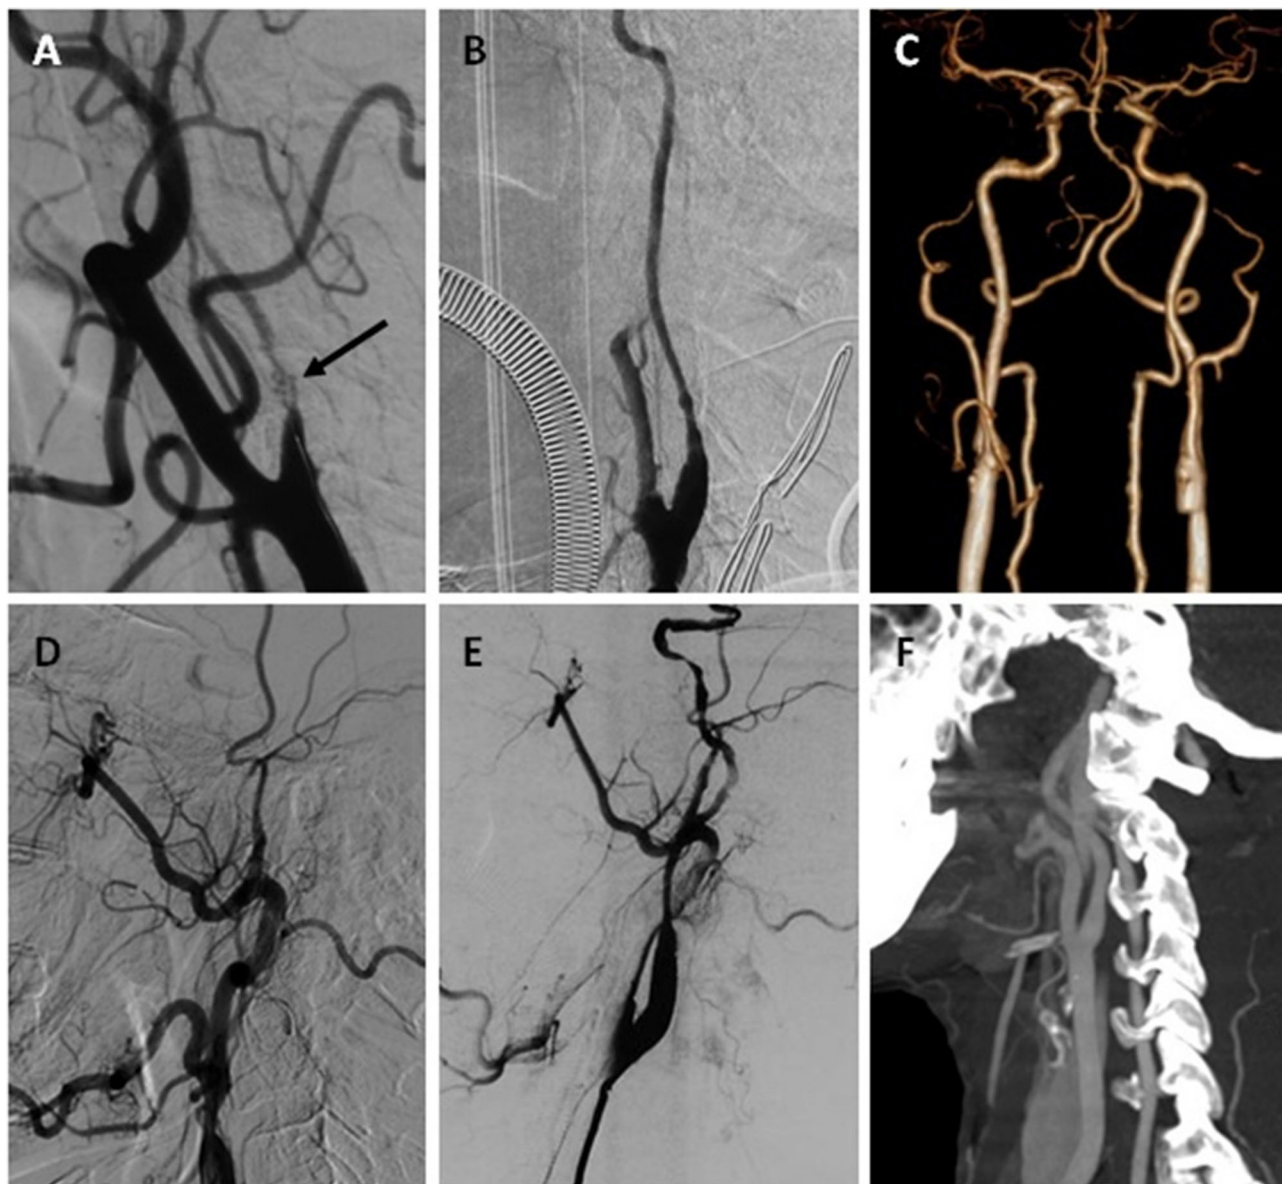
One ICANO and one ICACO with hybrid recanalization. Case-3 (A–C) A 56-year-old man complaining about TIA 2 years was hospitalized. (A) DSA before the hybrid surgery revealed a left ICANO with total occlusion and recanalization, which is characterized by multiple lumens (arrow). (B) Immediate angiogram of the left ICA after recanalization showed distal-narrowness. (C) CTA performed 1 week postoperatively showed a dilated left ICA. Case-4 (D–F) A 59-year-old man complaining of expressive aphasia 1 month was hospitalized. (D) Preoperative DSA revealed a left ICACO. (E) Immediate angiogram of left ICA after recanalization showed distal-narrowness. (F) (CTA) performed 1 week postoperatively showed dilated left ICA.
